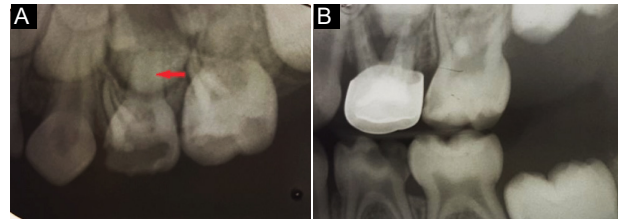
Lesion Sterilization and Tissue Repair Therapy for Left Maxillary First Primary Molar. A: Radiographic examination shows carious enamel and dentin with pulpal involvement in the maxillary first primary molar and also mild internal root resorption (arrow); B: 12 months after treatment, normal development of the subsequent first premolar bud is seen and the primary internal resorption of the first primary molar is not seen to progress.
